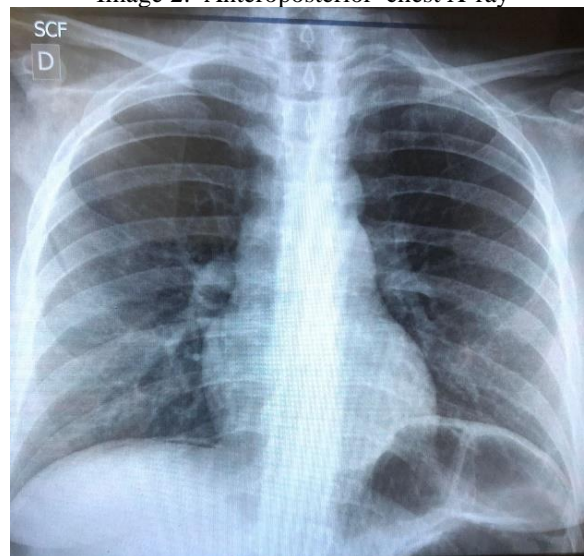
Anteroposterior chest X-ray
